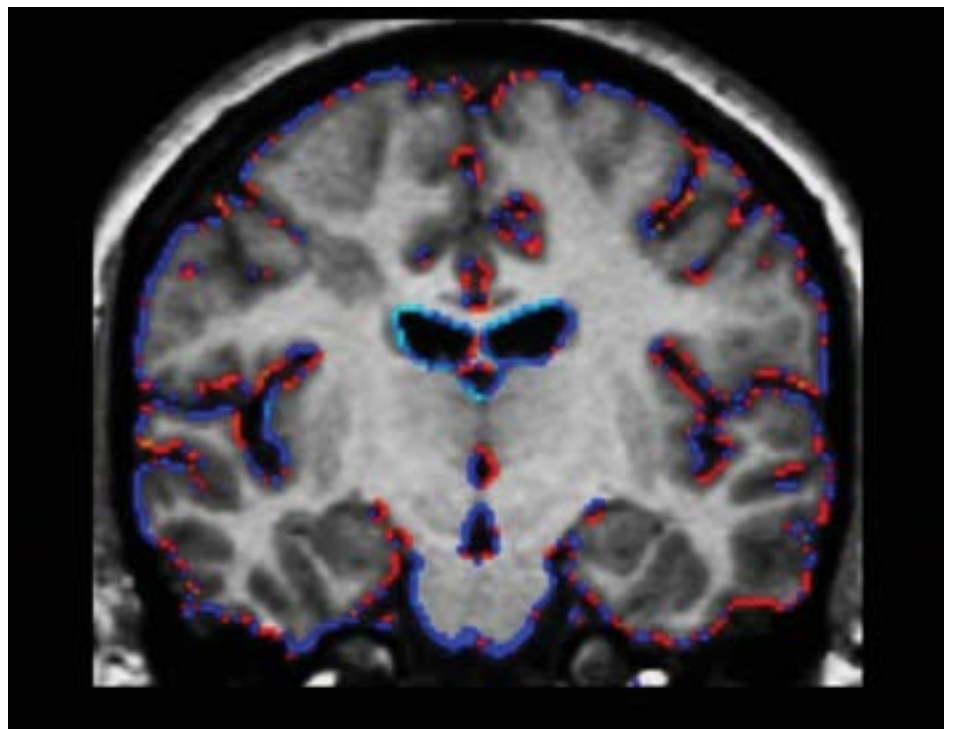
Brain volume loss in MS demonstrated using the 'Structural Image Evaluation, using Normalisation, of Atrophy' technique applied to two MRI scans acquired one year apart. A coronal brain slice is presented, rendered with a colour overlay, where blue indicates volume loss and red indicates gain. For further details see Anderson et al.¹⁰ Image courtesy of Valerie Anderson.
